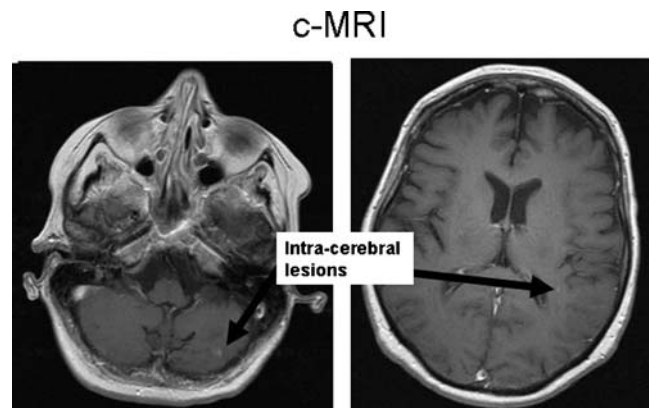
The cranial magnetic resonance imaging (MRI) showed two lesions most likely to be of infectious origin in the left parietal lobe and in the cerebellum
